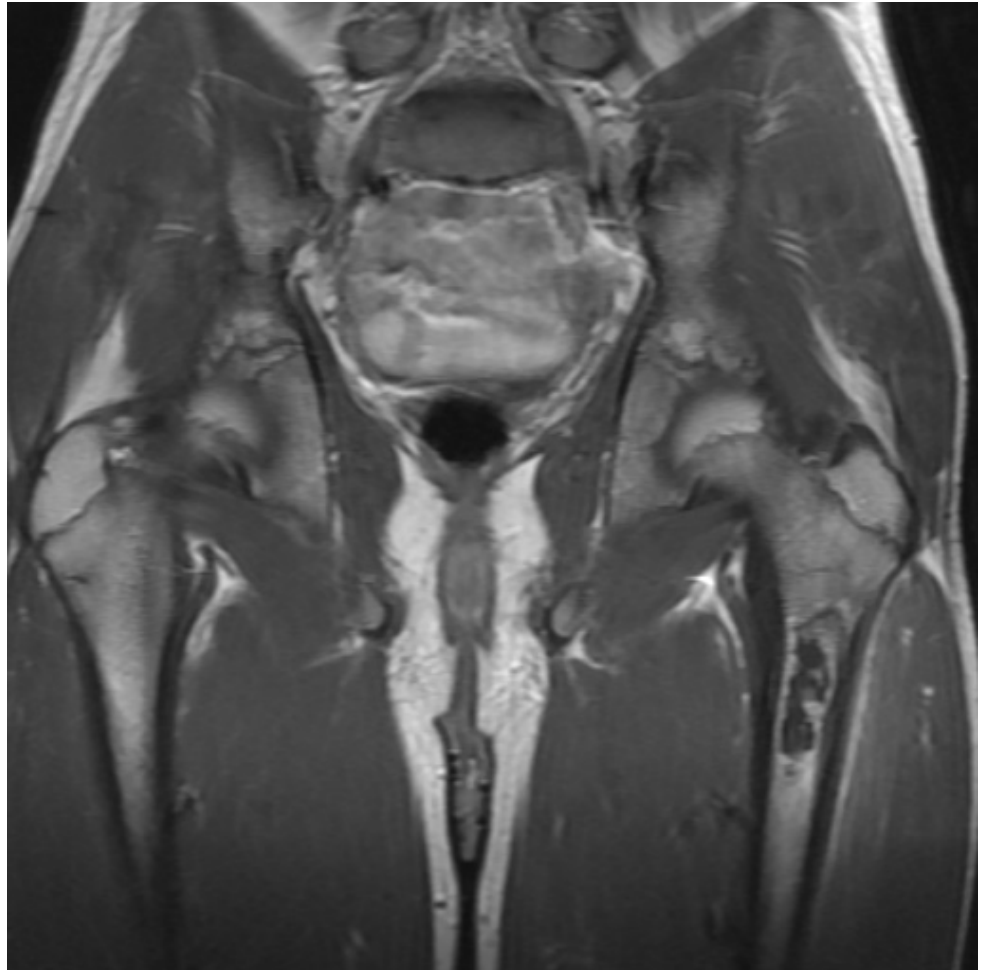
Magnetic resonance imaging showing osteomyelitis of the left proximal femur.
